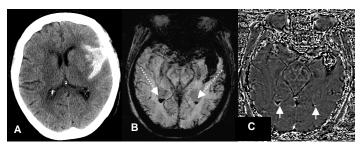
CT (A) showed high density in the sylvian cistern. SWI (B) not only showed hemorrhage in the same region, but also showed the blood level inside the ventricles (long arrows) which CT failed to show. SWI phase (C) showed blood products with aliasing effect (short arrows).
